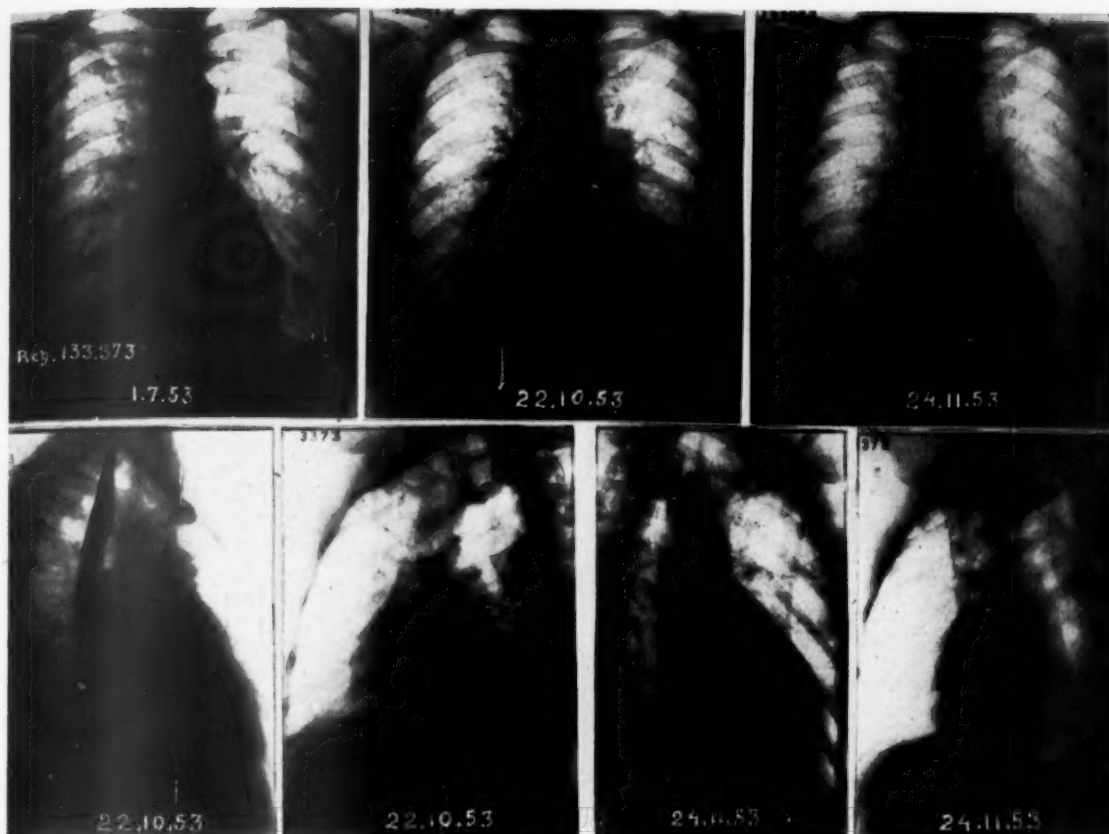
Case 2. The first x-ray taken routinely before the occurrence of cardiac decomposition shows slight enlargement of the left ventricle and a prominent aortic knob. On October 22, 1953 there is a definite increase in heart size and signs of pulmonary congestion. One month later the patient was completely asymptomatic with a marked reduction in heart size and no evidence of pulmonary vascular engorgement, as observed roentgenologically.
